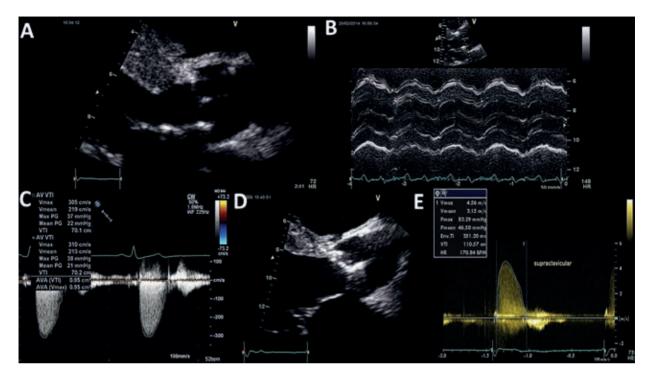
Echocardiography of normal and failing Perimount aortic valves. Note: 2A-C are baseline scans. 2A is a parasternal long-axis view and 2B an M-mode both showing thin leaflets. 2C is the continuous wave trace through the valve showing velocities within the normal range. 2D and E are recorded in a patient late after implantation who presented with breathlessness. 2D is a parasternal long-axis view in systole showing thickened and immobile leaflets. 2E is the continuous wave trace showing severely elevated velocities.
